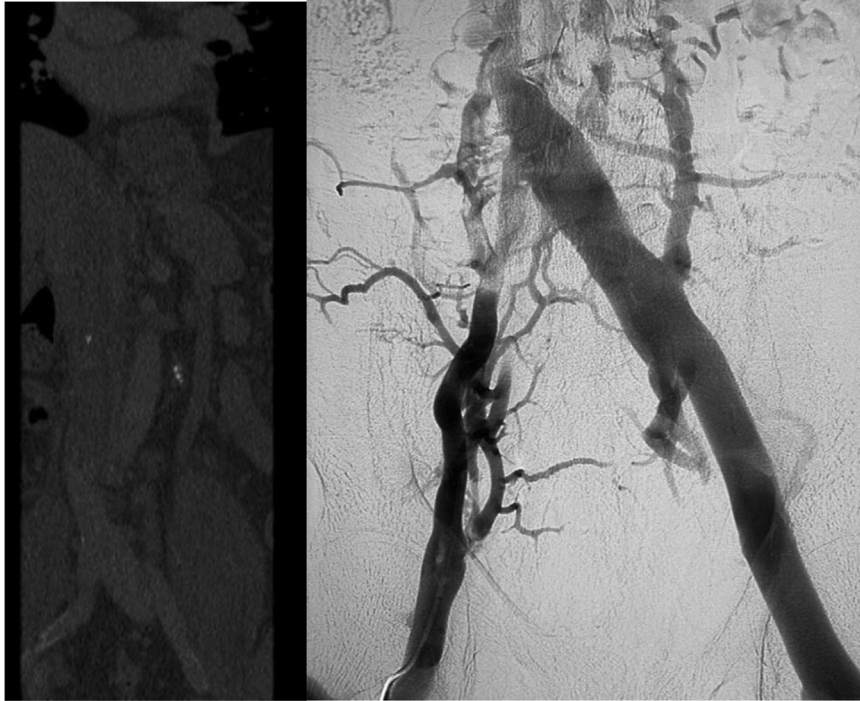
Left*, Extent of inferior vena cava (IVC) disease seen on magnetic resonance imaging (MRI). *Right*, Venogram showing engorged lumbar veins.
